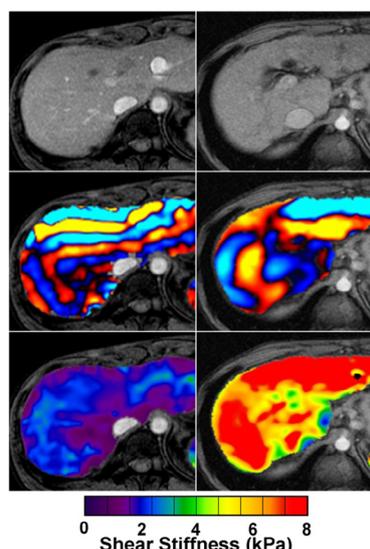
Normal liver is pictured on the left and the cirrhotic liver on the right. The top image is the MRI scan, the second row show the shear wave signal and the third, the integrated shear stiffness in kPa, colour coded as shown.
